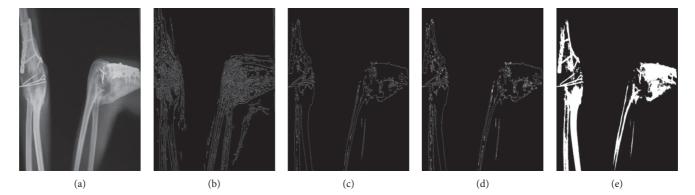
Comparison of ultrasound image reconstruction results of traumatic myositis ossificans of the elbow joint. (a) Original image. (b) Bicubic interpolation image. (c) FSRCNN image. (d) US-FSRCNN1 image. (e) FISTA image.
